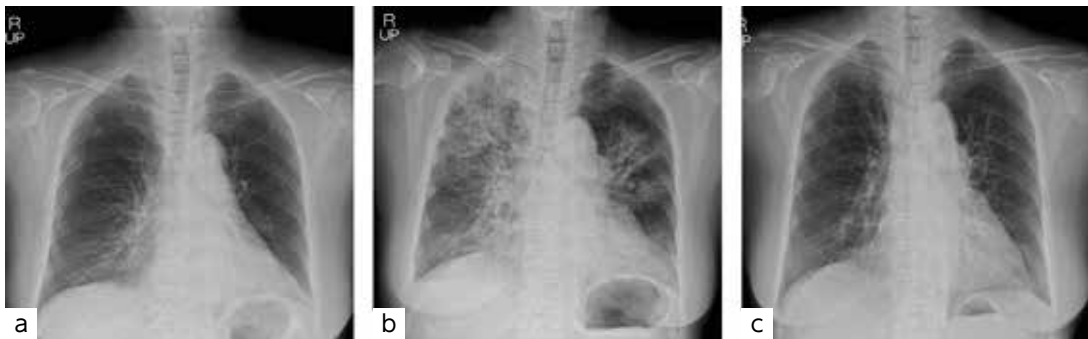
Chest X-ray findings
